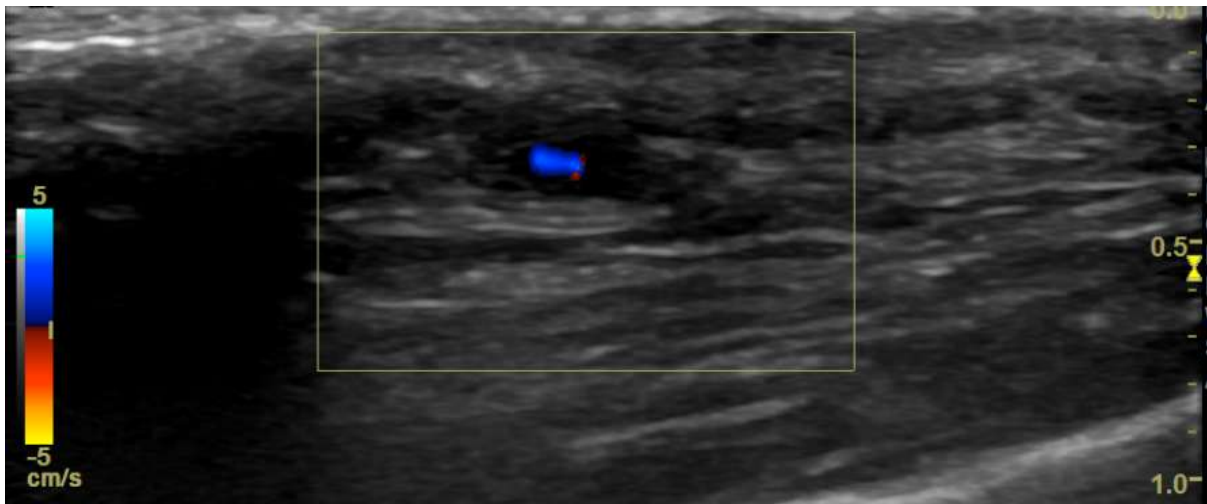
thickening of the artery with colour Doppler
